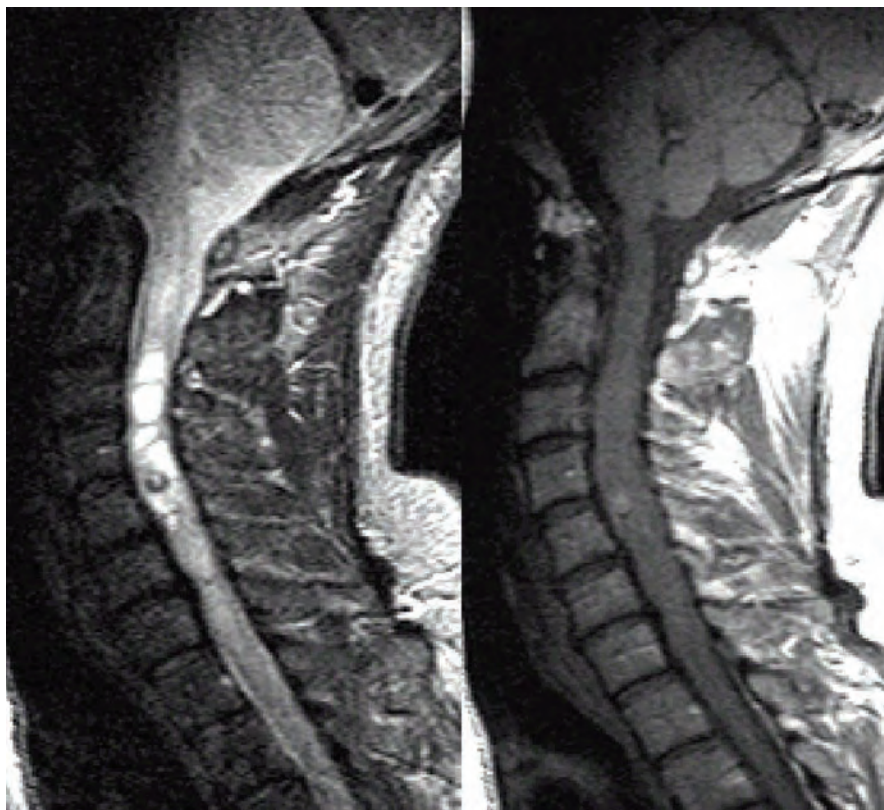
An ependymoma of the cervical spine on MRI T2 image (left) and T1 with contrast (right). Note the associated syrinx seen on T2, contrast enhancing mass on T1, and overall expansion of the cord.
